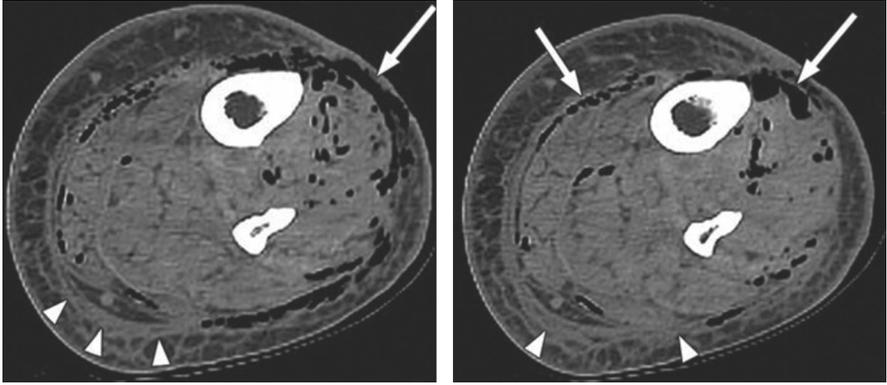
Two Axial CT Images of the left lower extremity of a patient with necrotizing soft tissue infection, demonstrating edema in the soft tissues (*arrowheads*) and air tracking along the fascial planes (*arrows*). (From Chaudhry A, Baker K, Gould E, et al. Necrotizing fasciitis and its mimics: what radiologists need to know. *AJR* 2015;204:133; with permission.)
